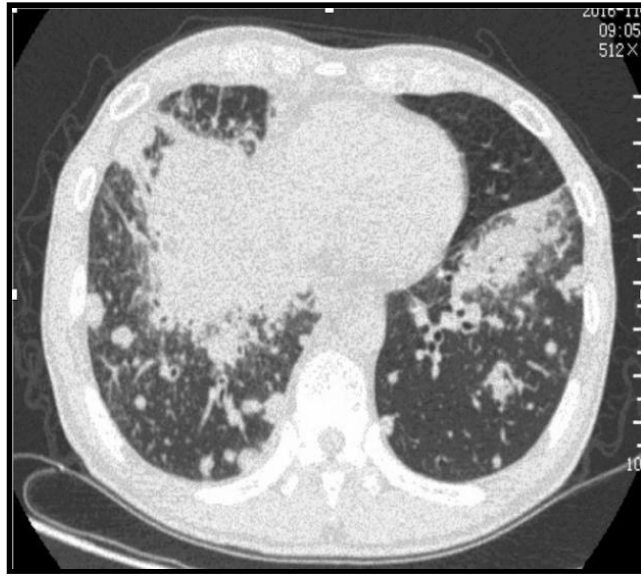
CT scan of the chest revealed bronchial obstruction of the right middle lobe and multiple lung nodules over the bilateral lung bases.
